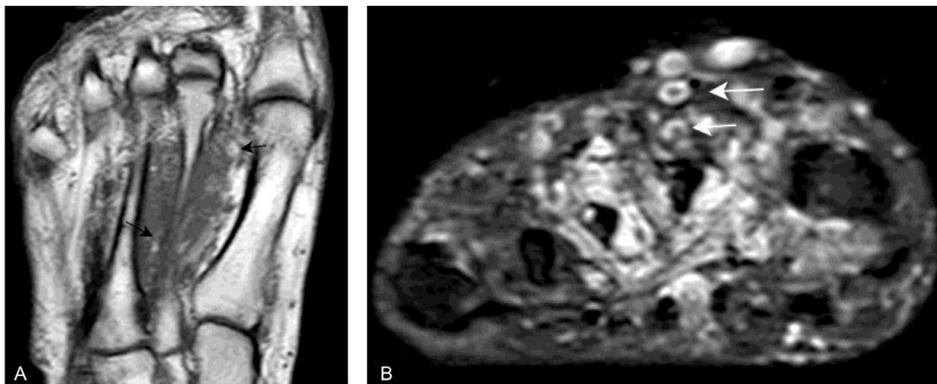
Hemangioma. (A) Axial long-axis T1WI shows an interdigitating mass around the first through third metatarsals with areas of high signal intensity (black arrows). (B) On coronal short-axis fat saturated T2WI, the lesion shows serpiginous high signal intensity. There are dot-like foci of low signal (white arrows) in keeping with phleboliths. T1WI, T1-weighted images; T2WI, T2-weighted images.
